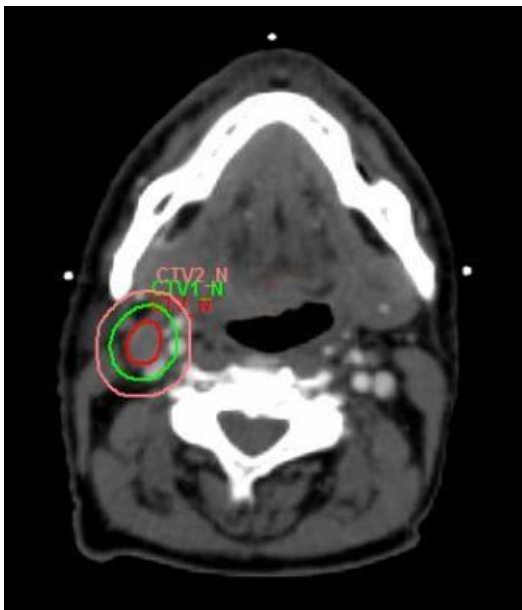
Cross sectional imaging of the phase 1 planning CT. GTV\_N contoured in red, CTV1\_N in green, CTV2\_N in pink
